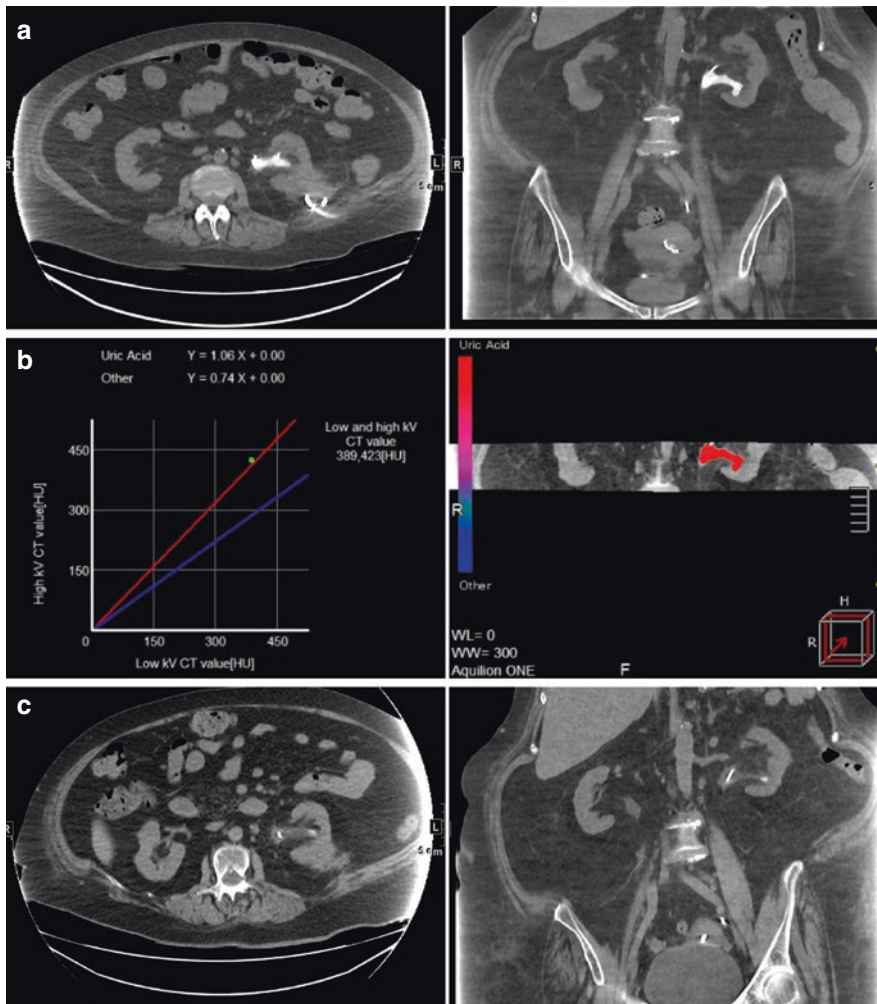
Urinary stone characterization with material decomposition algorithms. (a) Axial on coronal CT images showing a large stone in the left renal pelvis in an obese patient with left flank pain. (b) DECT-stone analysis
